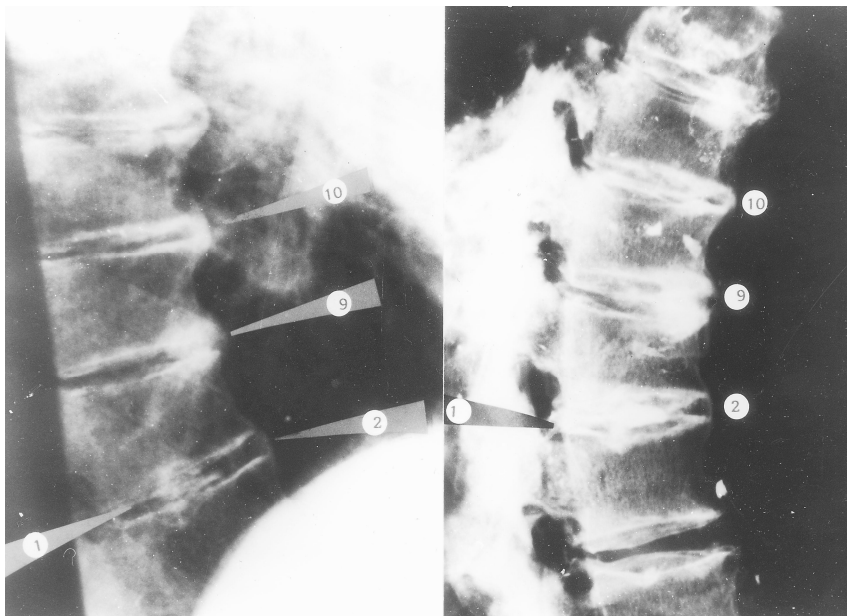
Antemortem (right) and postmortem (left) lateral radiographs of the thoracic spine (numbering corresponds to that in the text).
